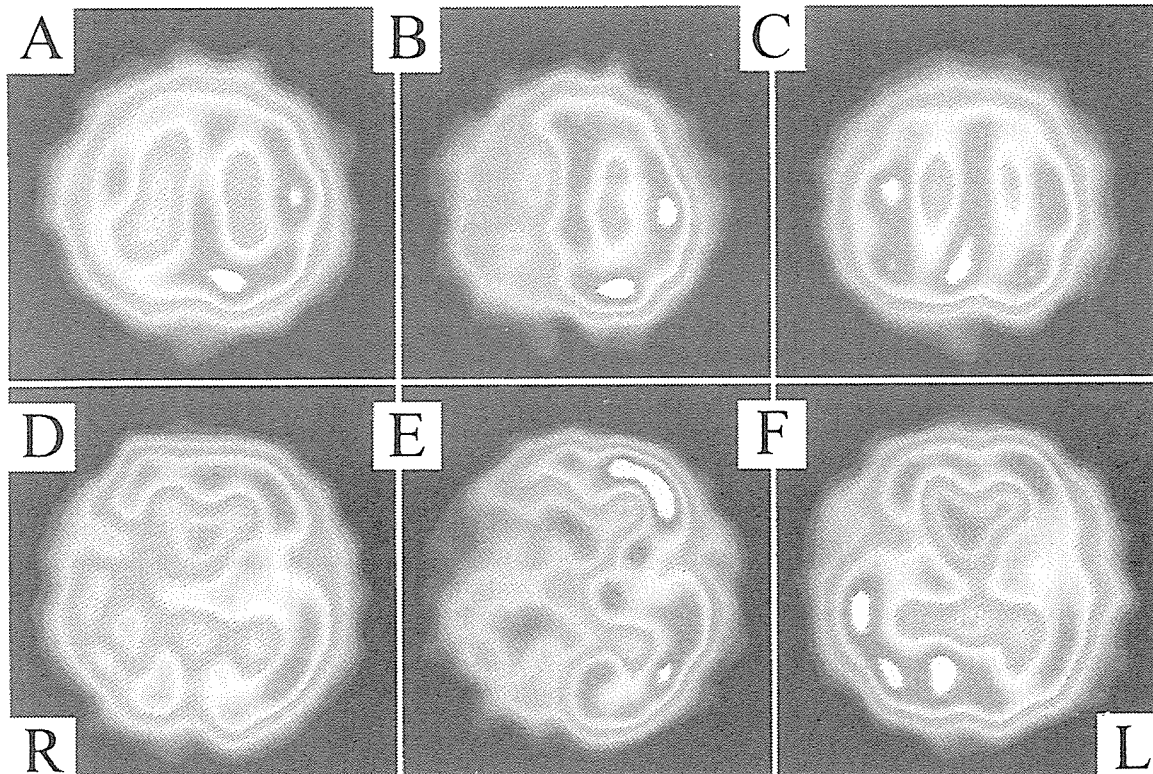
Case 2. A and D: Preoperative  $^{123}\text{I}$ -IMP SPECT scans showing severe hypoperfusion in the right hemisphere including the basal ganglia. B and E: Preoperative  $^{123}\text{I}$ -IMP SPECT scans obtained after acetazolamide infusion, revealing a marked decrease in vascular reserve in the right hemisphere including the basal ganglia. C and F: Postoperative  $^{123}\text{I}$ -IMP SPECT scans demonstrating improved CBF in the right hemisphere including the basal ganglia.
